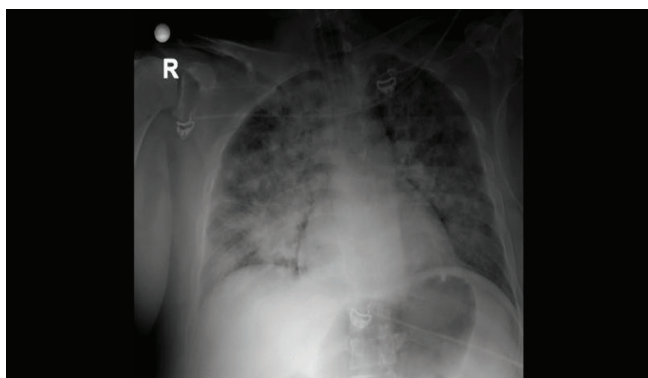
Chest X-ray image of widespread haemorrhagic areas in lungs
